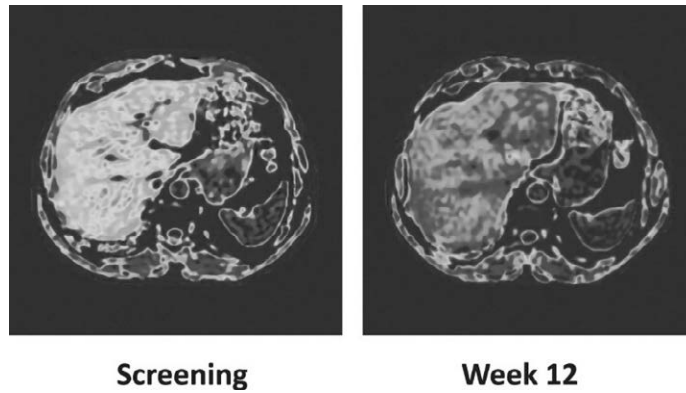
MRI-PDFF images for one patient treated with 50mg denifanstat
